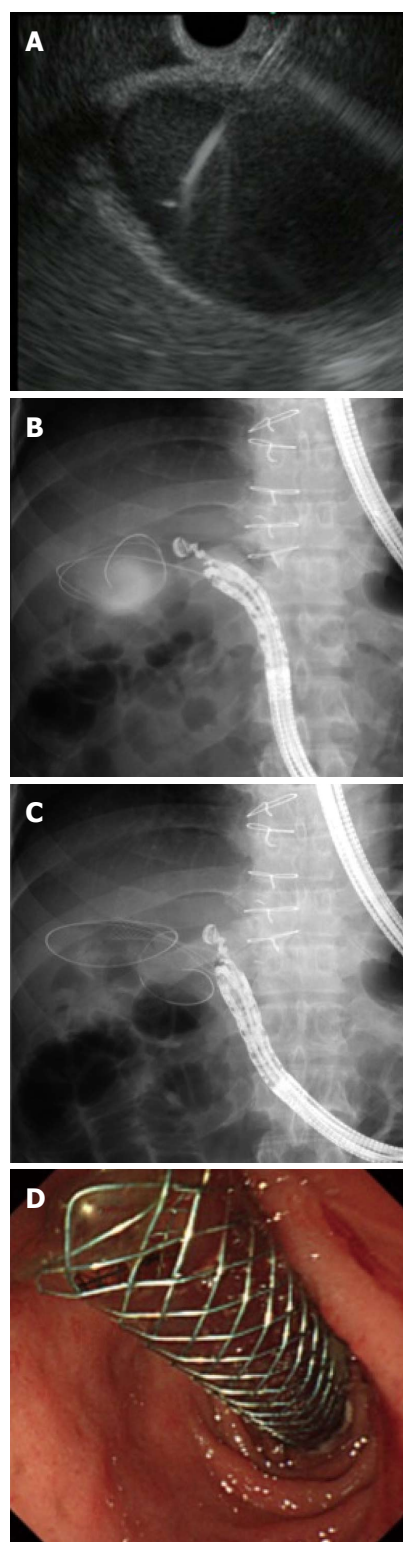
Endoscopic ultrasonography-guided gallbladder drainage. A: Endoscopic ultrasonography showing that the gallbladder was punctured by the needle; B: Guidewire was advanced through the needle into the gallbladder; C: A self-expandable metallic stent (SEMS) was placed between the gallbladder and the duodenum; D: Endoscopic view showing that distal end of a SEMS was located at the stomach.
